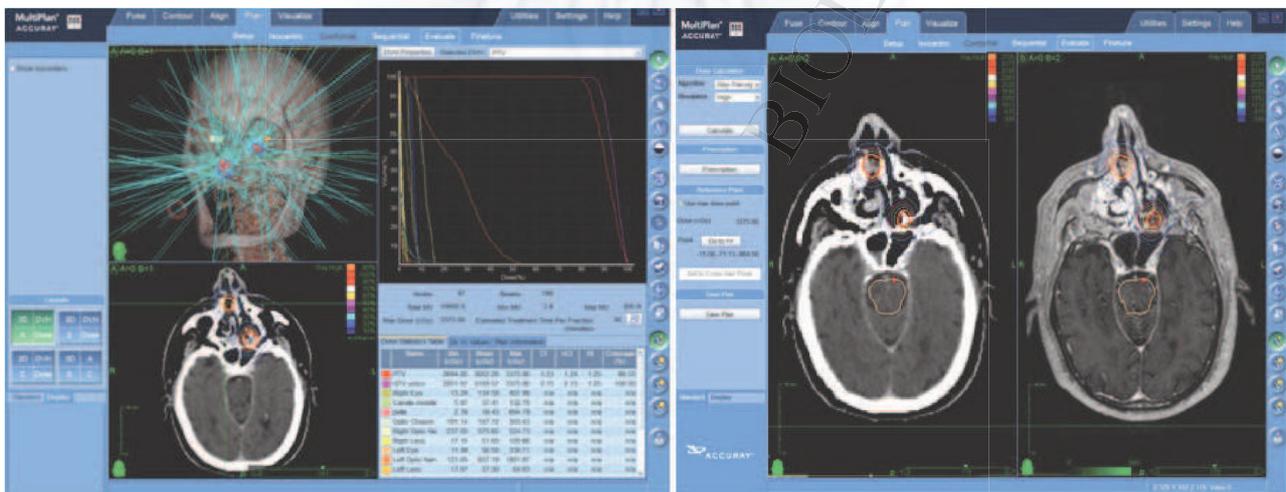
CyberKnife®-SRT. Contouring of target and organs at risk with simul-TC/MRI and DVH fusion images of treatment planning. The patient underwent CyberKnife® SRT with a total dose of 27 Gy at isodose line of 80% in 3 fractions.
